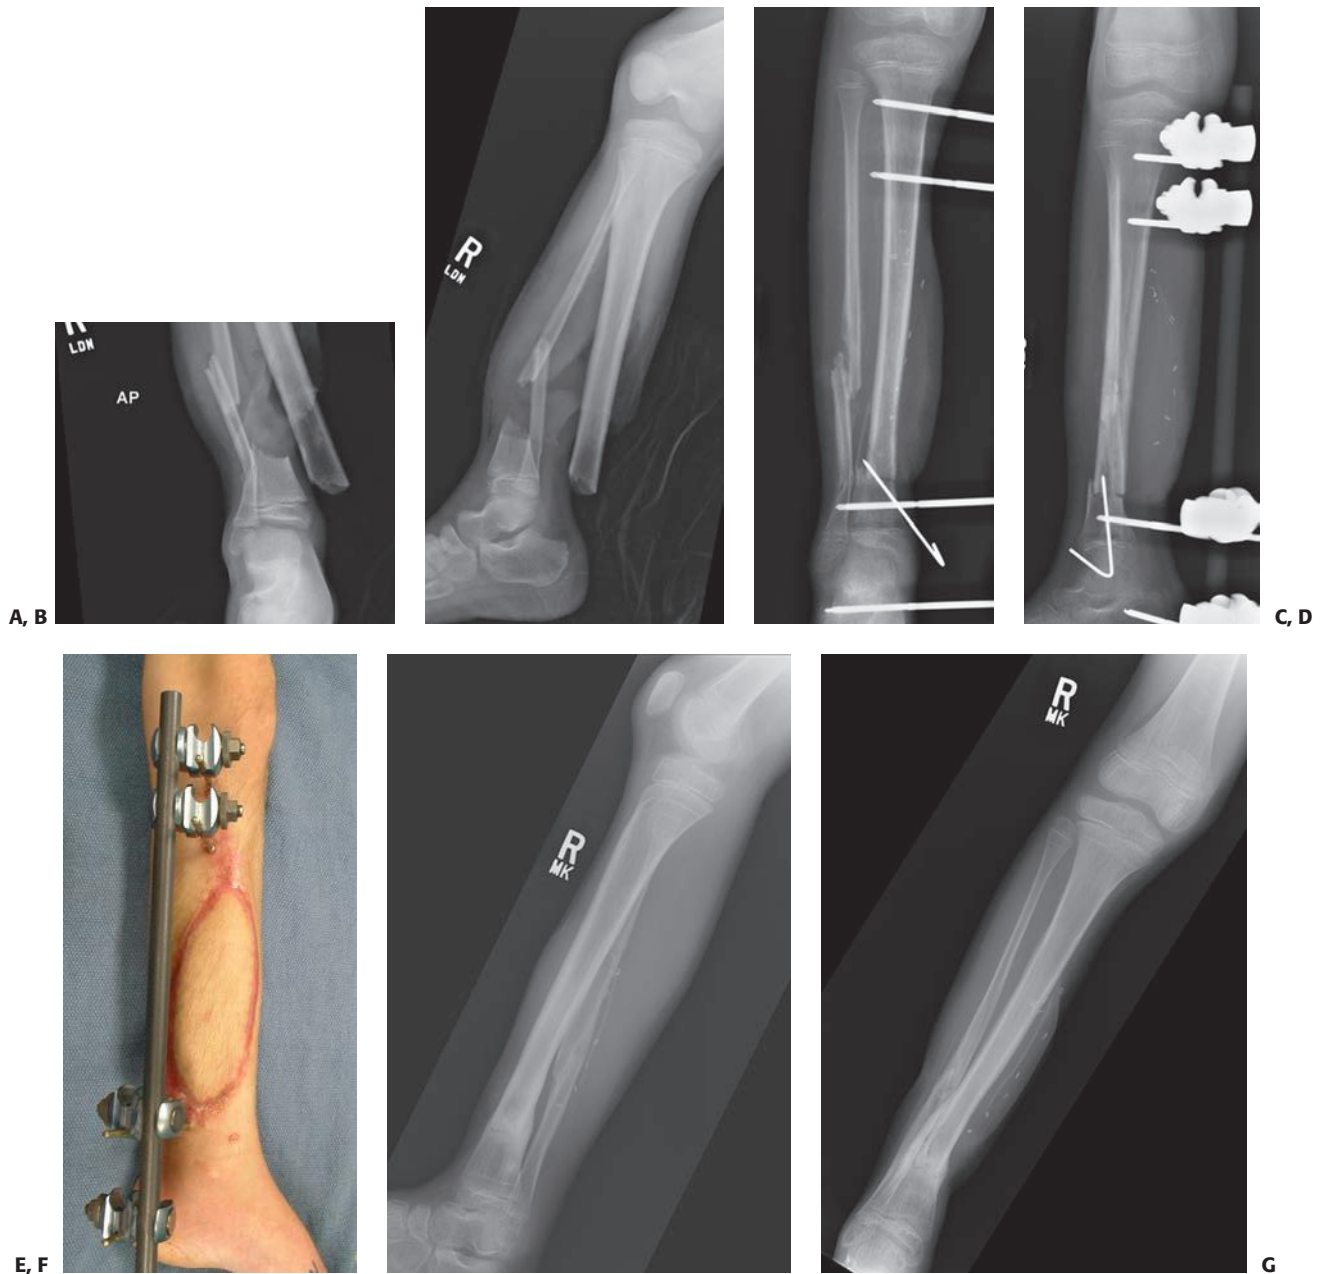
A and B: Anteroposterior and lateral radiographs of a grade IIIB open tibia/fibula fractures sustained by a 9-year-old male in an agricultural accident. C,D,E: Anteroposterior/lateral radiographs, and clinical image of a patient 8 weeks after placement of spanning monolateral external fixator with additional percutaneous pin fixation, and delayed coverage with anterior thigh free flap. F and G: Anteroposterior and lateral radiographs of a patient 9 months post injury. Patient had excellent clinical result.
